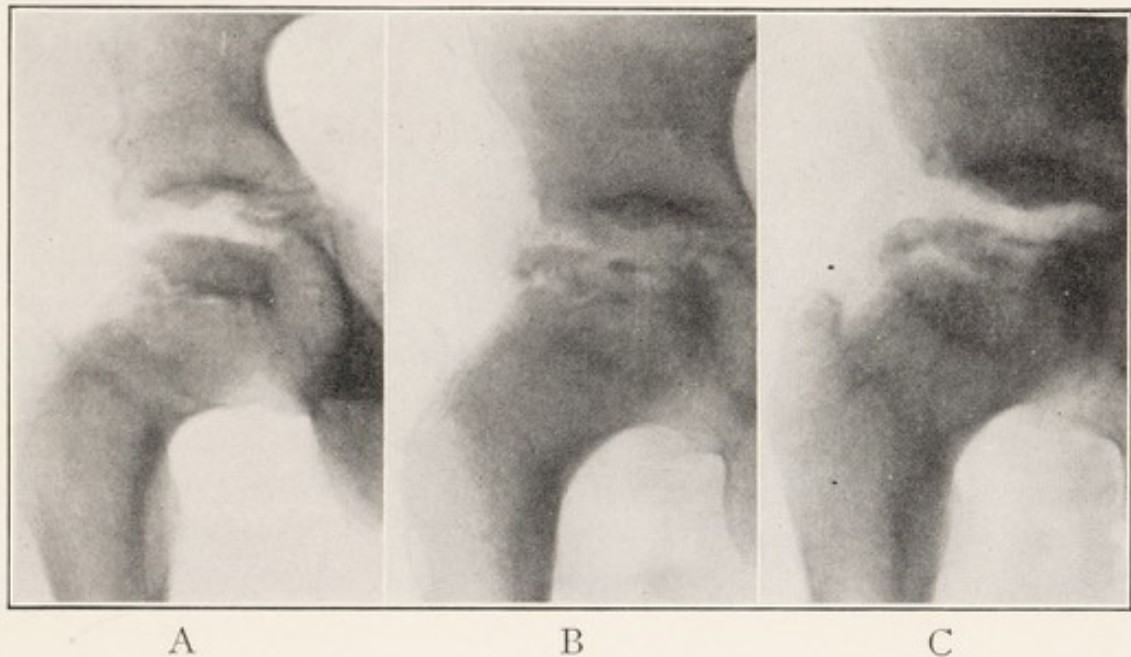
X-RAY SERIES OF COXA PLANA, SHOWING PROGRESSIVE FLATTENING AND FRAGMENTATION OF HEAD AND BROADENING OF NECK OF FEMUR.
